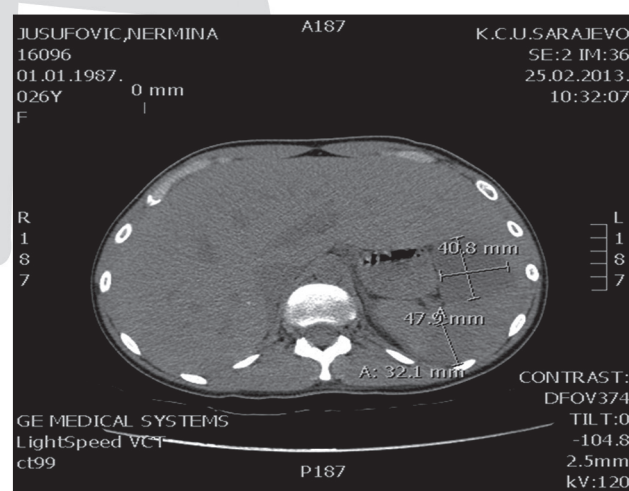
CT image zone splenic infarction
